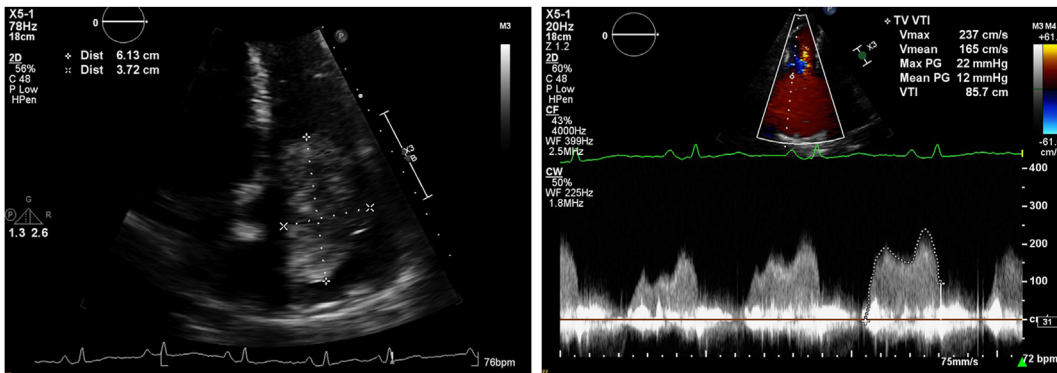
Two-dimensional TTE showing a 6.0 cm RA mass prolapsing into the right ventricle on apical 2-chamber view (left), as well as tricuspid flow obstruction with a mean gradient of 10 mm Hg on color-flow Doppler (right).
